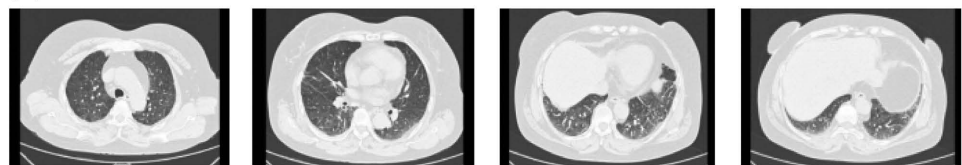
Imaging changes before and after glucocorticoid therapy (A) Chest CT scan before glucocorticoid therapy (B) Chest CT scan after nearly 2 months of glucocorticoid therapy (C) Chest CT scan when the condition worsens after 10 months of glucocorticoid maintenance therapy (D) Chest CT scan after 6 months of adjusting the glucocorticoid therapy regimen.
